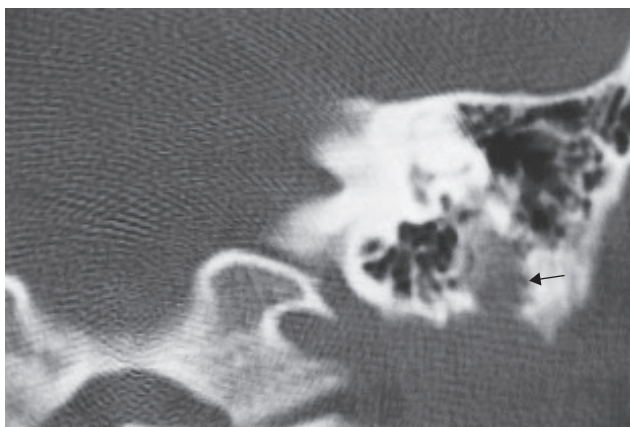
CT scan of Fallopiian canal containing a facial nerve schwannoma. The canal is expanded and its bony margins are scalloped (arrowed).
